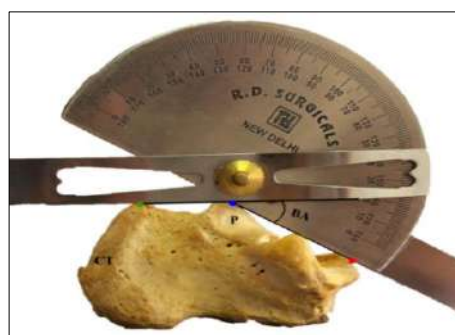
showing the measurement of the Bohler's angle (BA) by the goniometer. Red dot indicates anterior most point of the calcaneus, blue dot indicates the superior most point of the posterior articular facet and green dot indicates the superior most point of the calcaneal tuberosity. CT represents the calcaneal tuberosity and P represents the posterior articular facet.
